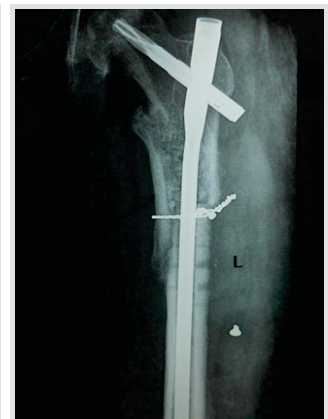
Pre-operative AP X-ray of case eight showing subtrochanteric nonunion with implant failure.
